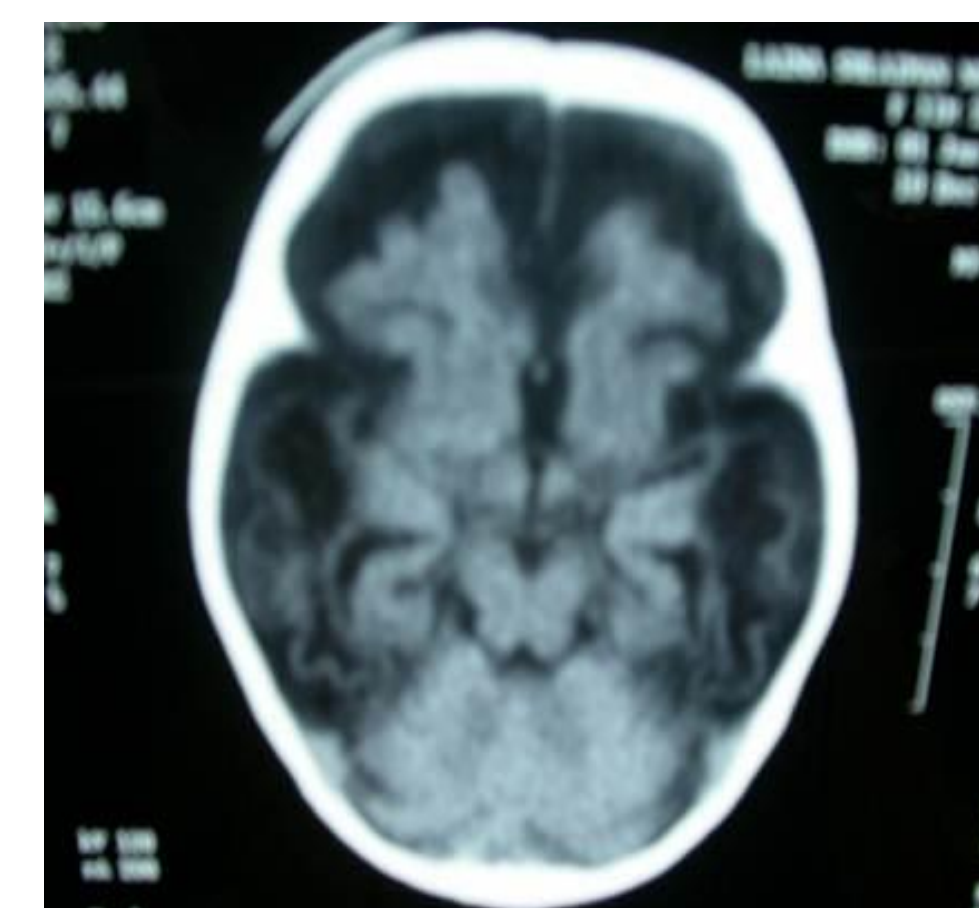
CT brain showing severe brain atrophy in neonate with primary lactic acidosis (Cytochrome C oxidase deficiency)
